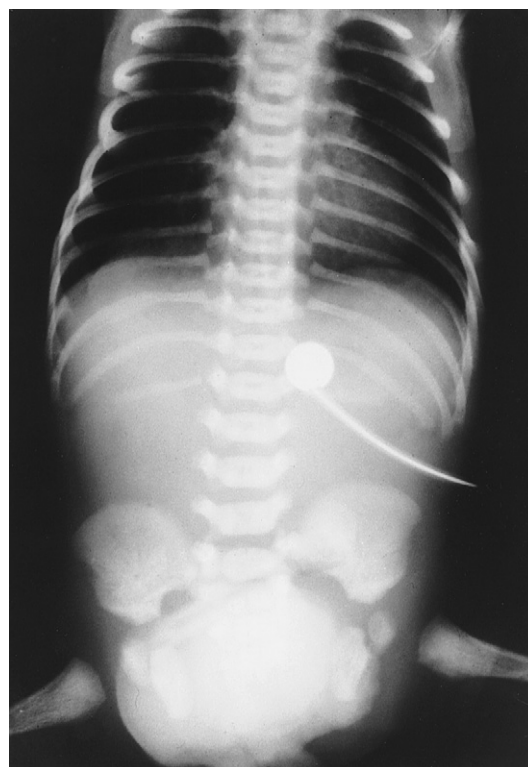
Plain radiograph of a neonate with bladder exstrophy demonstrates the soft tissue mass effect of the exposed bladder, the wide diastasis of the symphysis pubis, and the posterior rotation of the acetabula.
